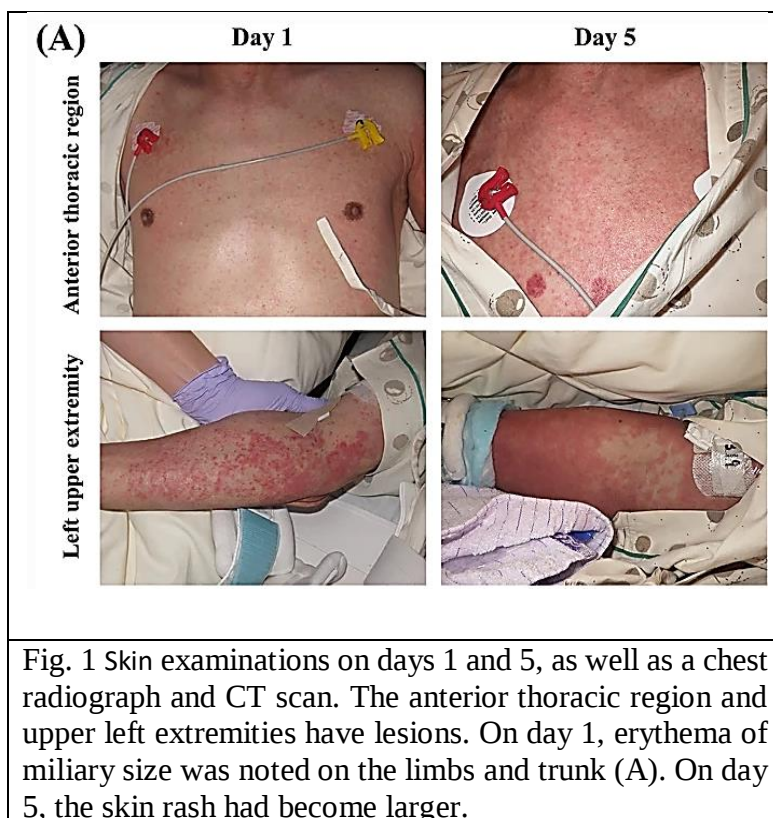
Skin examinations on days 1 and 5, as well as a chest radiograph and CT scan. The anterior thoracic region and upper left extremities have lesions. On day 1, erythema of miliary size was noted on the limbs and trunk (A). On day 5, the skin rash had become larger.
